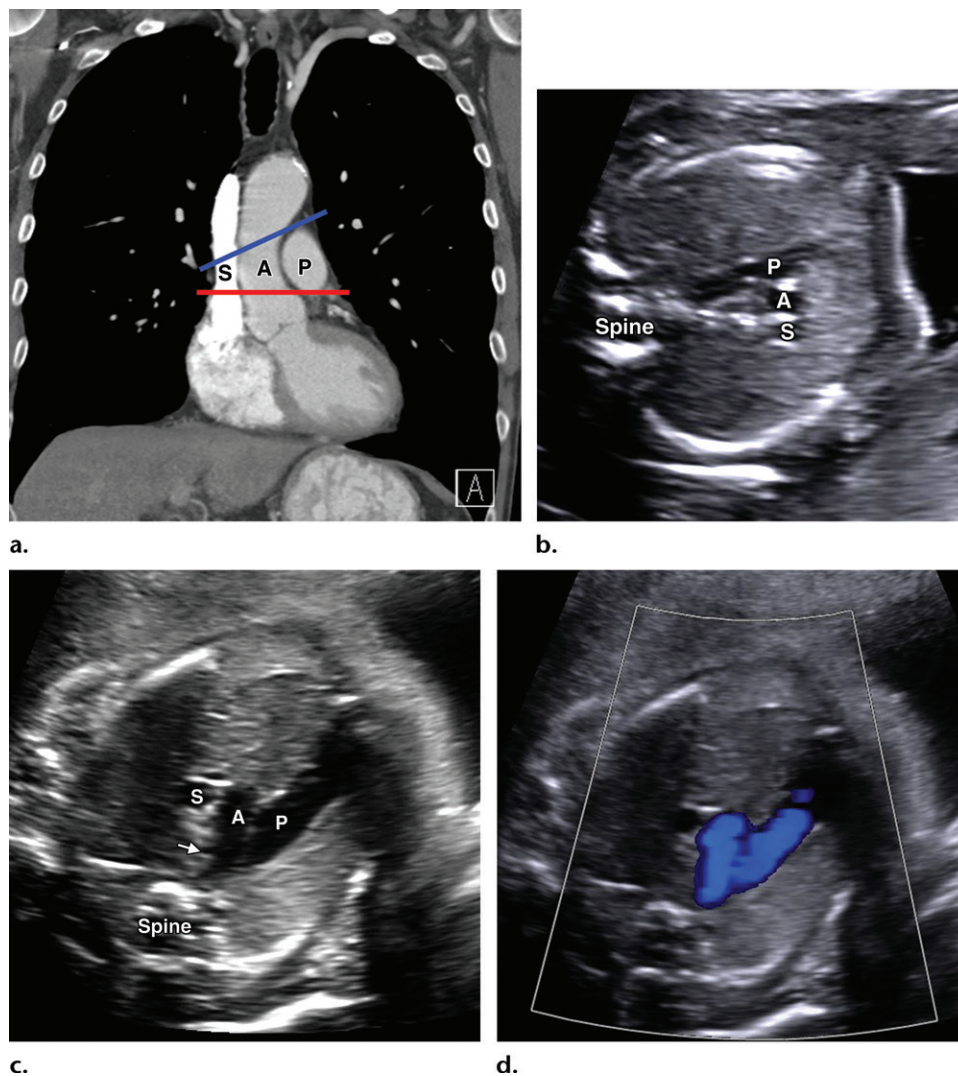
3VV and 3VT. A = aorta, P = PA, S = SVC. (a) Coronal enhanced CT image shows the approximate scan planes for the 3VV (red line) and 3VT (blue line). (b) Axial fetal US image shows a normal 3VV with the SVC, the aorta, and the PA as it continues posteriorly into the ductal arch. (c) Axial oblique US image shows a normal 3VT with the SVC and the fluid-filled trachea (arrow). The aortic and ductal (PA to ductus arteriosus) arches come together in a V shape to the left of the trachea. Note that the PA is slightly larger than the aorta. (d) Color Doppler image at the same level shows that the direction of flow is the same in both great vessels. With duct-dependent CHD, one of the great vessels fills retrogradely from the ductus. If this occurs, the direction of flow (ie, color) in the limbs of the V will differ.
